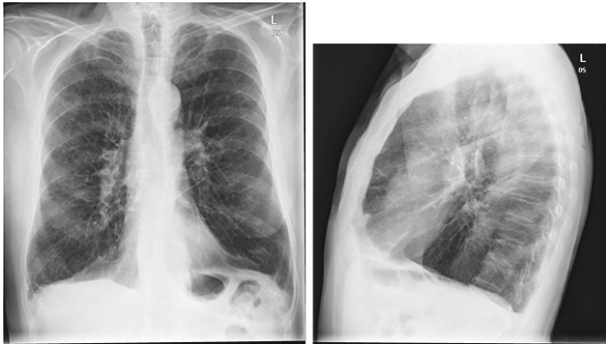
Posterior-anterior and lateral chest x-rays from a patient with COPD. Hyperinflation, increased retrosternal airspace, flattened diaphragms, and equalization of the anterior-posterior and lateral dimensions, “barrel chest” are demonstrated.
